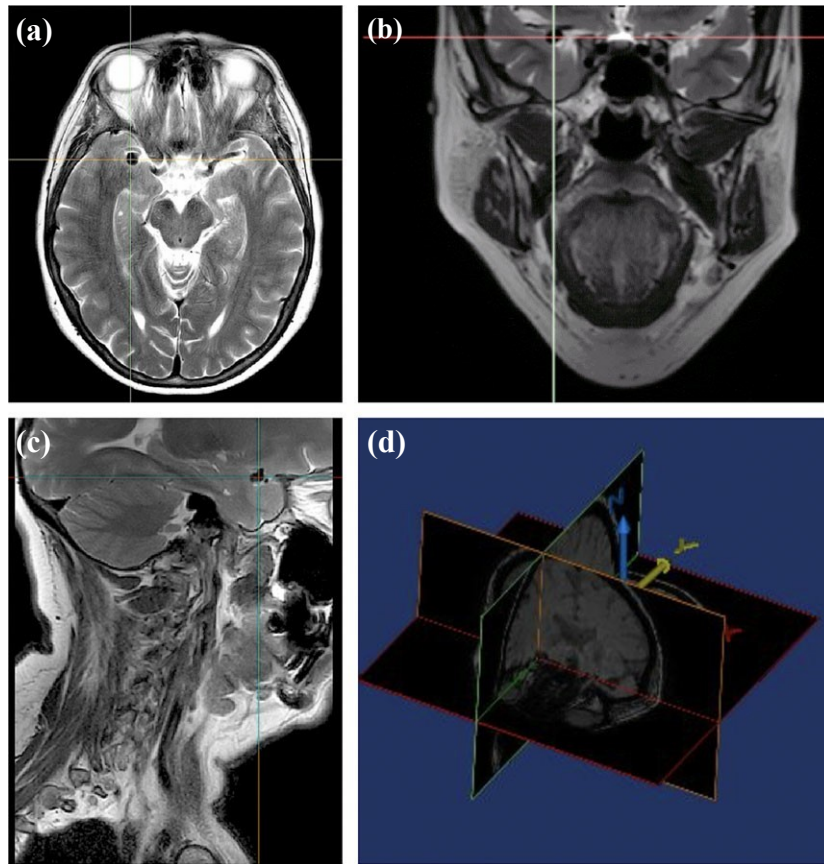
(a) Inferior transverse, (b) Anterior coronal and (c) Right sagittal Magnetic Resonance Images (sections) showing the middle cerebral artery (MCA) aneurysm, and (d) A three-dimensional reconstruction showing the aneurysm in the right MCA within the insula. The location of the aneurysm is shown by the point of intersection of the perpendicular planes.
